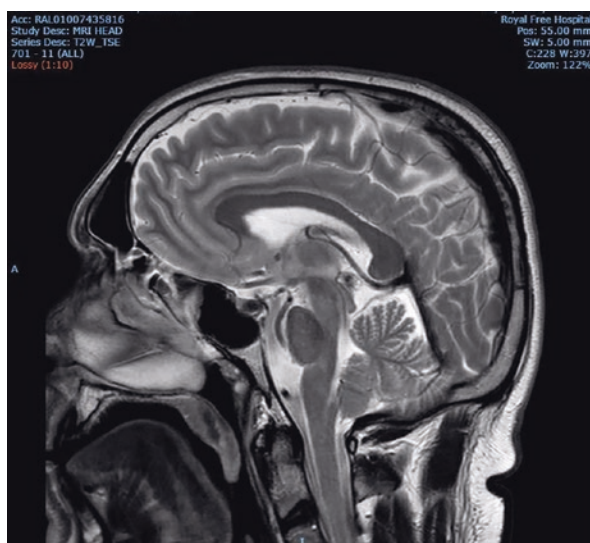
T2 weighted sagittal MRI showing no evidence for cerebellar or brainstem atrophy, nor for a lesion at the foramen magnum
